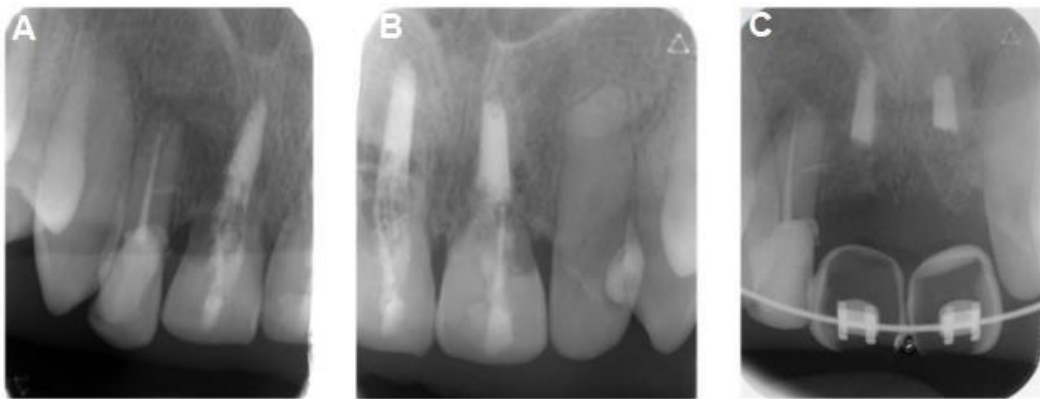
Periapical radiograph showing root resorptions of teeth 11 and 21 (A and B), prior to their extraction and replacement with veneers bonded to the orthodontic arch (C). Munoz-Sanchez et al., 2021
